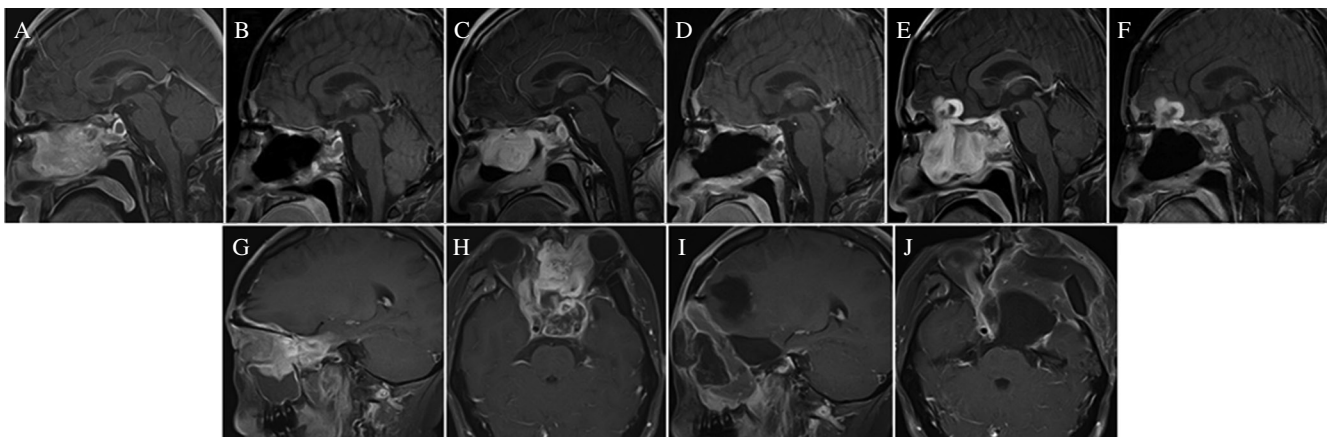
Gadolinium-enhanced T1-weighted MRI at 84 (A), 87 (C), and 92 months (E) after initial surgery demonstrating recurrent tumors extended to the left anterior skull base, nasal cavity, and parasellar lesion. Each recurrent tumor was subtotally removed by endonasal endoscopic salvage surgery at 84 (B) and 87 (D) months after initial surgery. We could not remove all tumors at 92 months after initial surgery (F). Gadolinium-enhanced T1-weighted MRI before (G, H) and after (I, J) radical resection at 95 months after initial surgery demonstrating that the tumors were removed gross totally.
